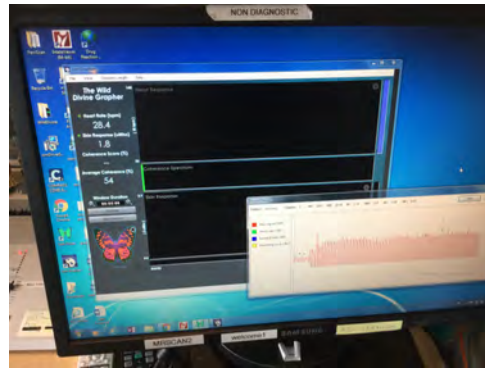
Testing of skin conductance sensors in MRI room
